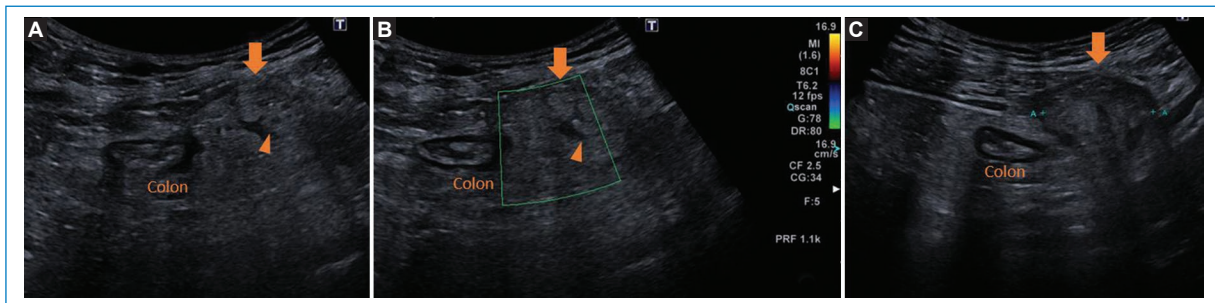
A 48-year-old male who presents to the emergency department for acute pain in the left iliac fossa, without fever, nausea or vomiting. A-C: an ultrasound was performed whose findings were a non-compressible hyperechoic image (arrows) without internal vascularization (B) and with a thin hypoechoic line in its interior (arrowhead), whose diagnosis was epiploic appendagitis.
